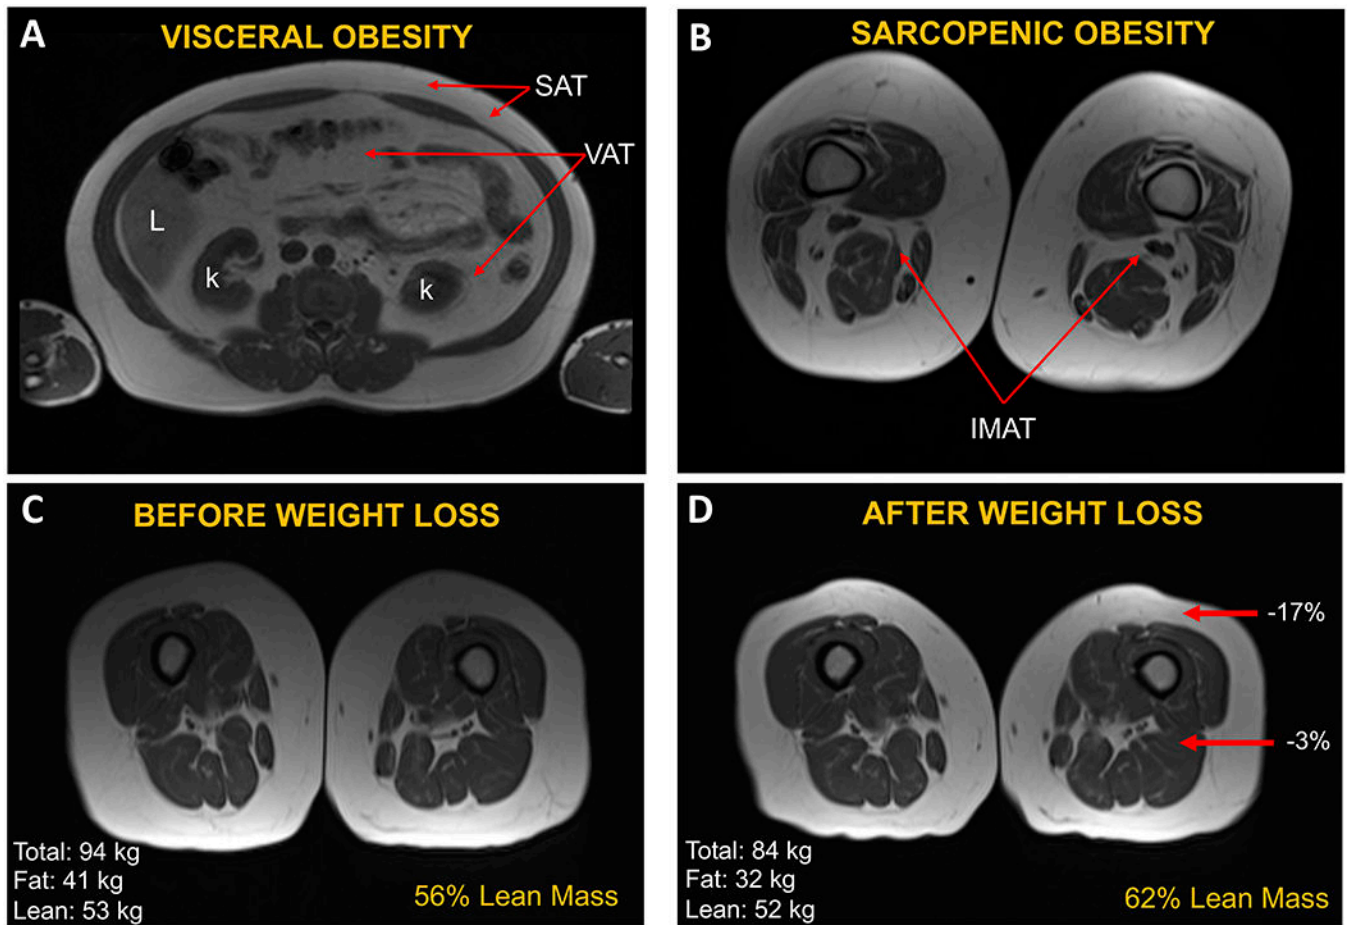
Skeletal muscle and adipose tissue in older adults suffering from obesity by MRI.
